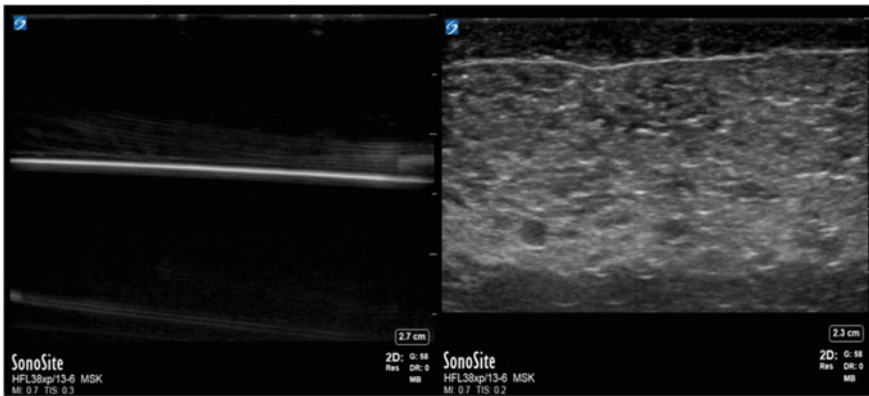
Ultrasound of oil/water solution (unmixed and mixed)
